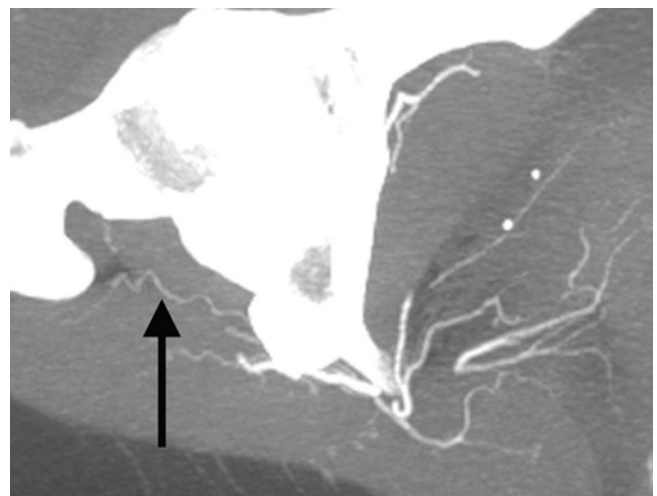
Maximum intensity projection image of the angio-CT scans showing the piriformis branch (*arrow*) of the inferior gluteal artery (Reproduced with permission and copyright © of the *British Editorial Society of Bone and Joint Surgery* [14])
